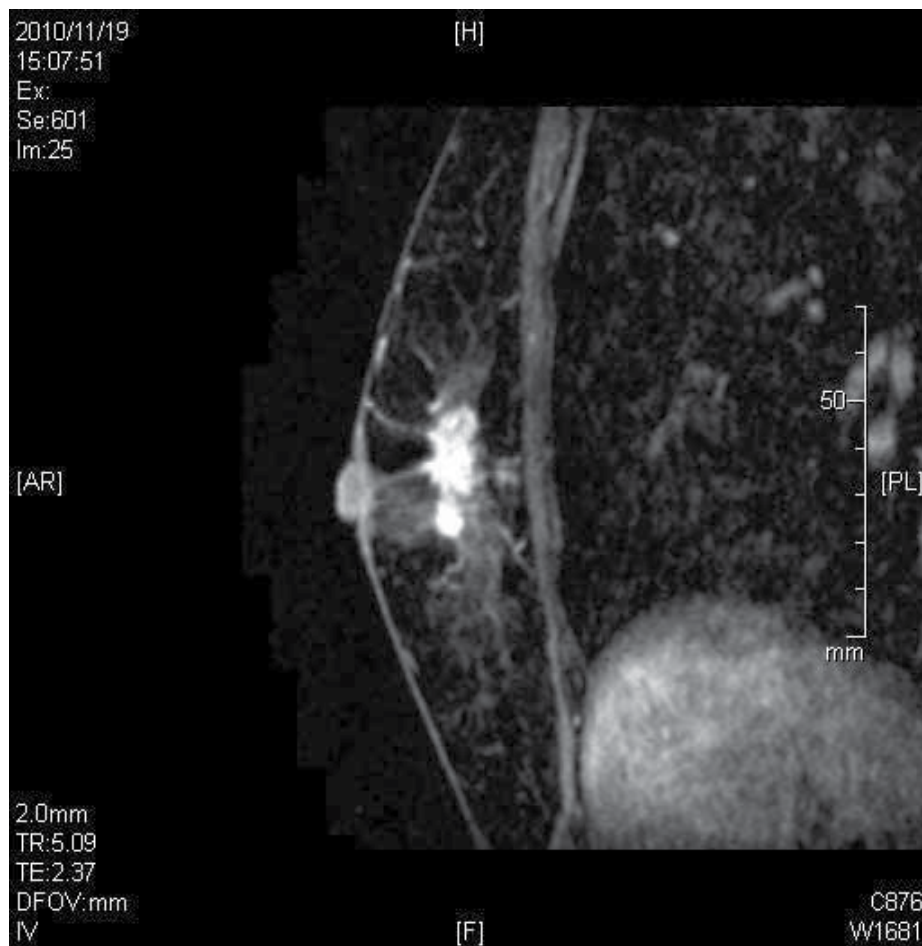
A second representative case of DCIS, MRI.
